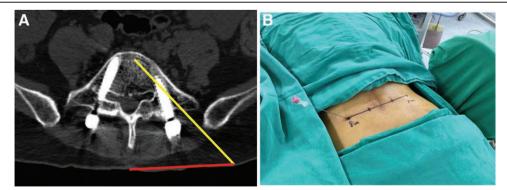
A, Preoperative axial CT scan showed the entry point was 8.2 cm lateral to the midline (red line) with tilting 47° trajectory (yellow line) to the target point. B, entry point of spinal needle.
